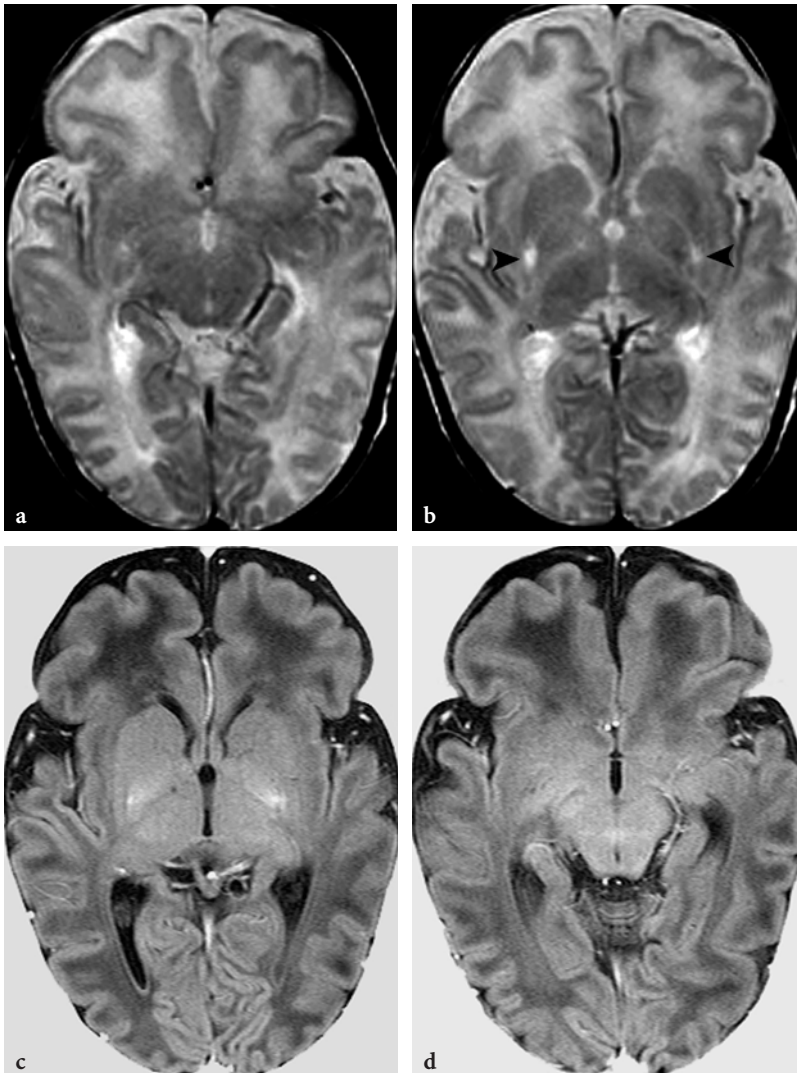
MR imaging findings in a 15-day-old (term) male patient with isovaleric aciduria. a, b. Axial T2-weighted fast spin-echo images. Subtle and ill-defined hyperintensities are seen within the posterior parts of putamina (*arrowheads*). The brain appears to be underdeveloped; note the immature cortical gyral pattern in the frontal and temporal regions. The white matter in the frontal lobes exhibits an increased signal intensity. Only traces of myelin are seen within the ventrolateral thalamic nuclei and tectum on these images. c, d Axial T1-weighted inversion recovery images. These images confirm the very poor overall myelination of brain. Practically no myelin is seen within the posterior limbs of the internal capsules, which indicates delayed myelination
